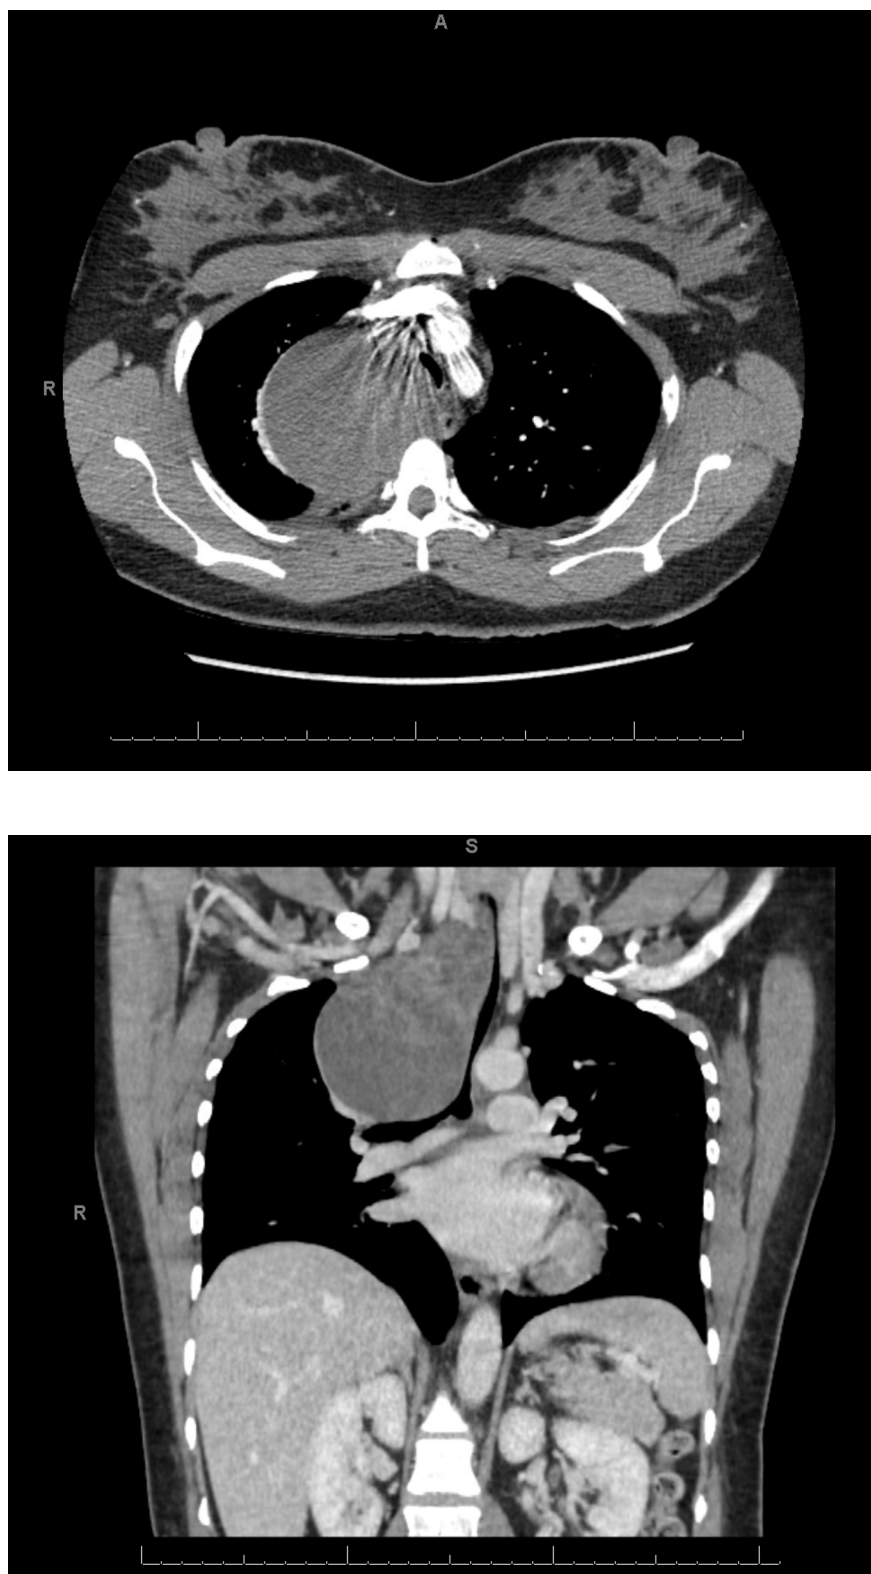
Axial (a) and coronal (b) CT images with 8 cm x 10 cm x 7.4 cm, non-enhancing, low-attenuation
